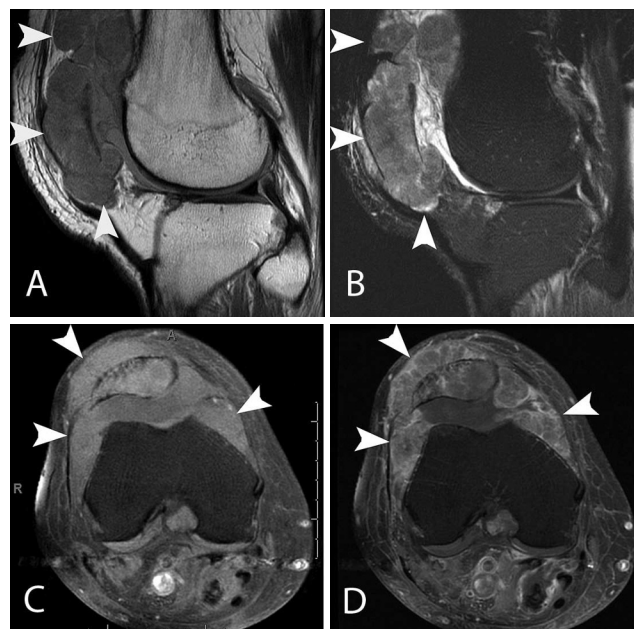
MRI of the knee shows extensive tumor (arrowheads) in the soft tissues along the ventral aspect of the distal femur, within the joint space, and involving the patella. The tumor showed heterogeneous enhancement following contrast administration. A. Sagittal T1-weighted MR of the knee. B. Sagittal T2-weighted, fat-saturated MR of the knee. C. Axial T1-weighted, fat-saturated MR of the knee. D. Axial T1-weighted, fat-saturated MR of the knee after administration of intravenous contrast material.
